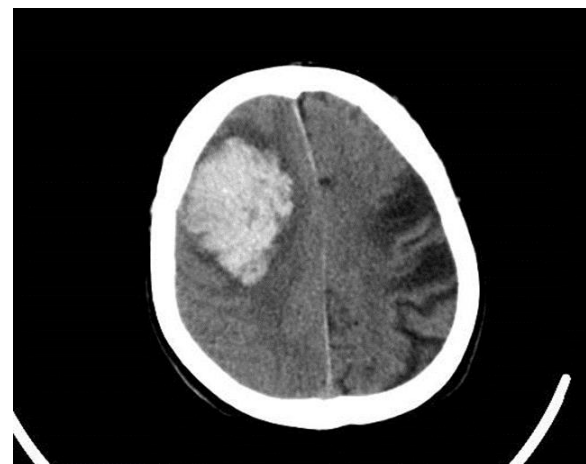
Brain CT Scan OF PATIENT
